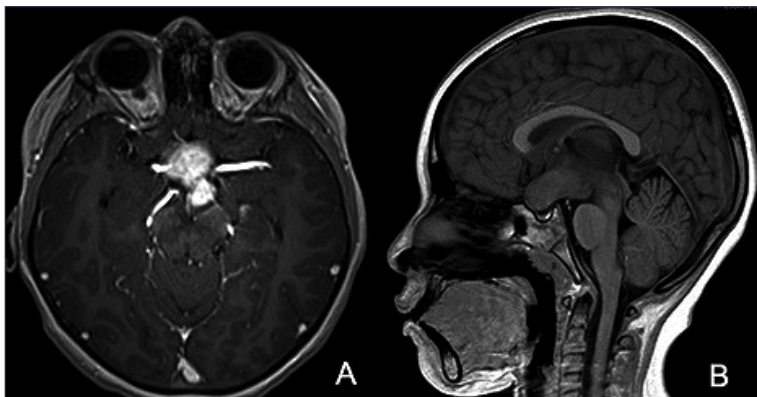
Initial study. A. Contrast MRI in axial slice where a hyperintense image is observed in the sellar region which enhances the 30.6 x 24.9 mm contrast medium; B. T1-weighted MRI in sagittal slice where an isointense image is observed that displaces the hypothalamus ventrally and occupies the entire interpenduncular cistern.
